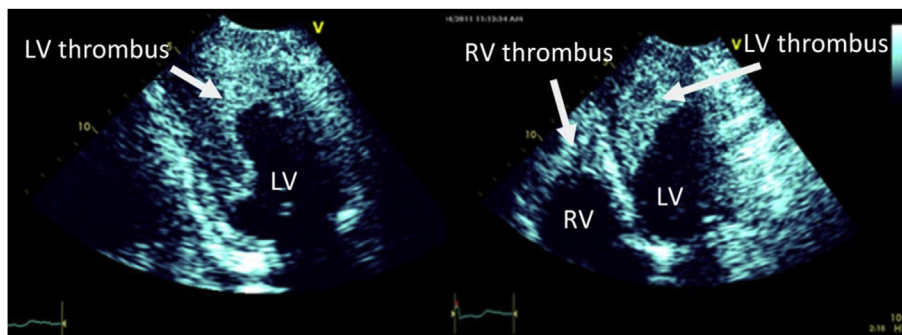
Transthoracic ECHO, showing large thrombi in ventricles.
